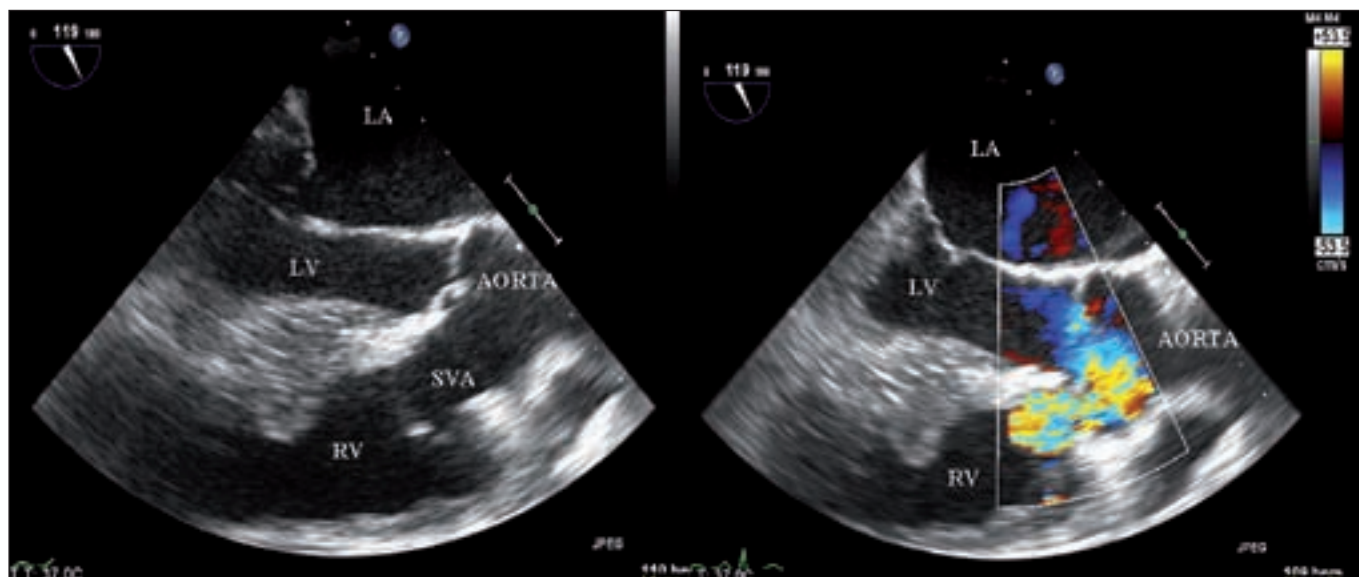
Transoesophageal echocardiography shows a ruptured aneurysm of the right coronary sinus with an obligate left-to-right shunt into the right ventricle, using colour Doppler technique (left). LV=left ventricle, LA=left atrium, RV=right ventricle, SVA=sinus of Valsalva aneurysm.
